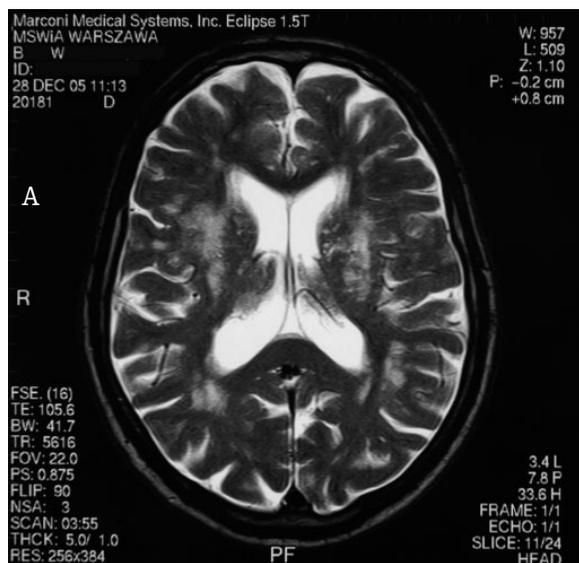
a, b. 53 year old woman with 16 year history of SSc and 3 year history of depression and severe episodes of headache; no focal deficits on neurologic examination; CT revealed mild/moderate atrophy: MRI, FSE, T2-weighted and FLAIR images: mild/moderate atrophy, multiple confluent focal lesions of leukoaraiosis type.
